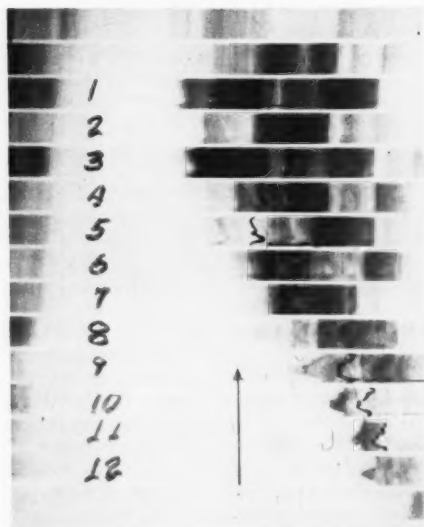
Roentgenkymogram of normal male, aged 35 years.
